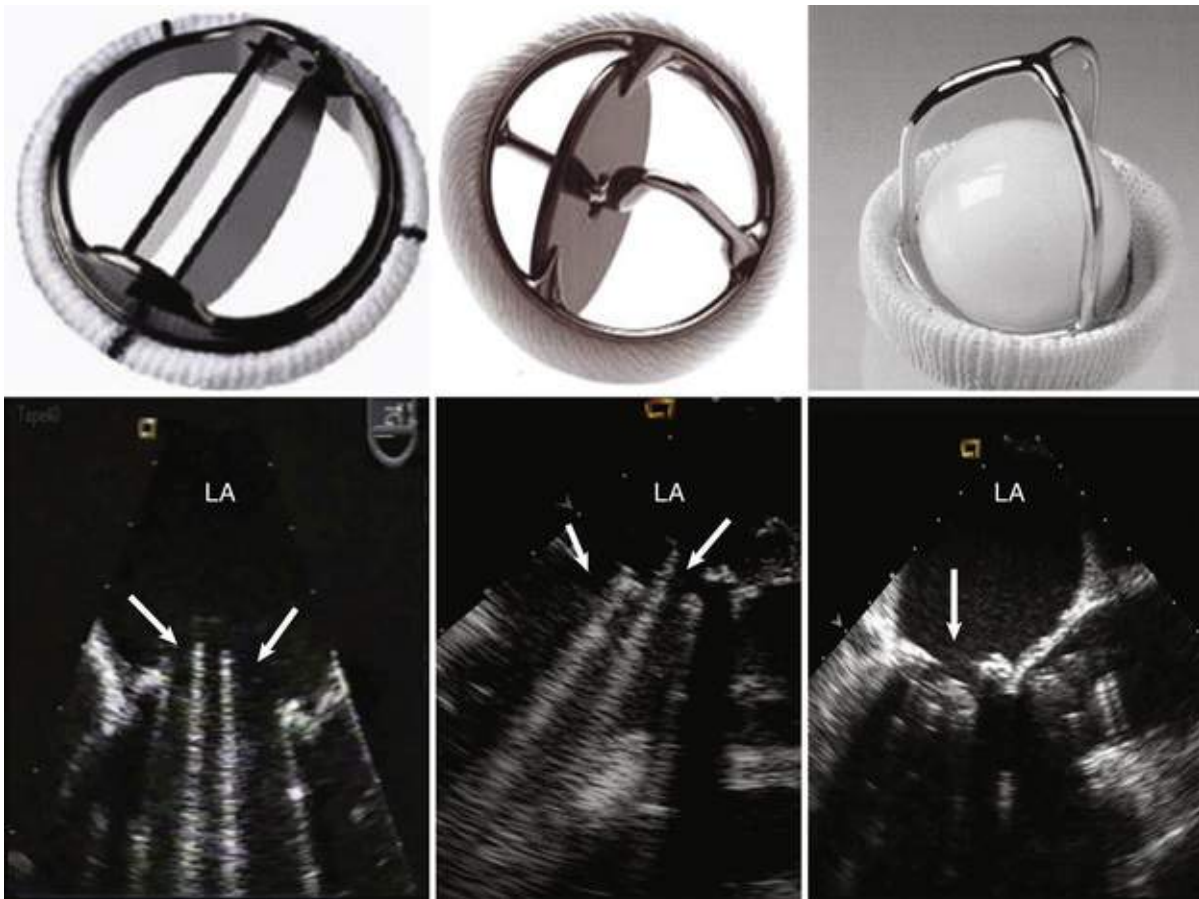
Mechanical prostheses and their transesophageal echocardiographic (TEE) appearance when implanted in the mitral position. Left panels, St. Jude bileaflet valve. *Arrows* indicate discs in the open position. Middle panels, Medtronic-Hall tilting single disc valve. The *right arrow* indicates the disc in the open position, and the *left arrow* indicates reverberation from the central pivot. Right panels, Starr Edwards ball-and-cage valve. The *arrow* points to the valve in the open position. *LA*, Left atrium.
